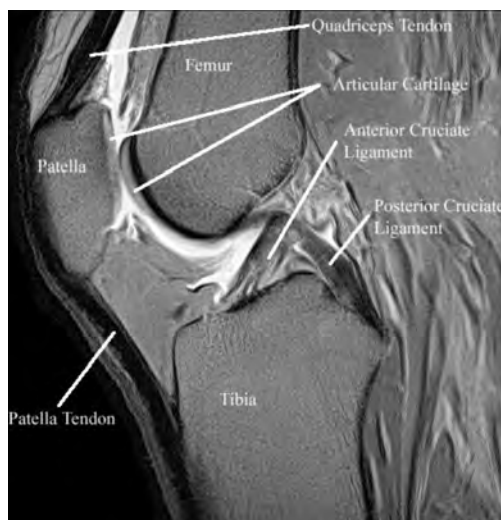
Sagittal MRI image showing anatomy of the knee. (ortho pics – knee pics)
